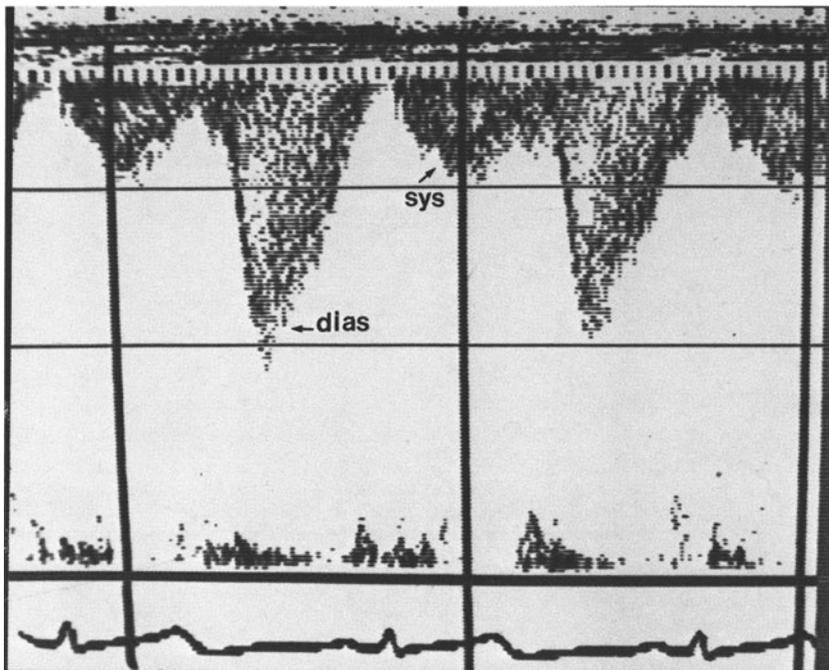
A Doppler trace from a Mustard patient demonstrating a dominant diastolic with a smaller systolic peak.
